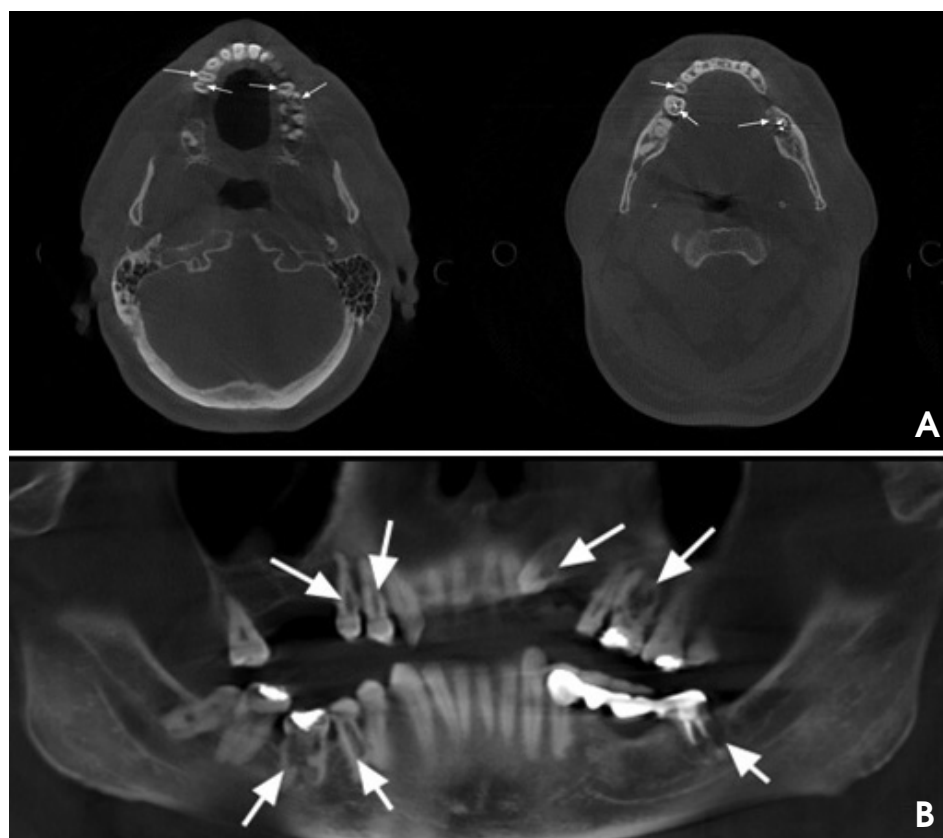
A. Axial cone-beam computed tomographic images show sites of idiopathic resorption of the teeth. B. Panoramic reconstructed image clearly demonstrates the resorptive areas.
